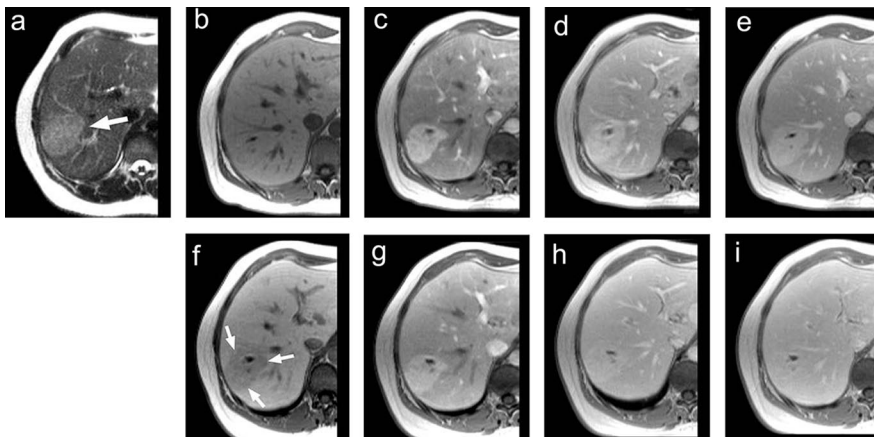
Hepatic adenoma in a 37-year-old female patient. A large lesion (arrow) is clearly seen in liver segment VII as slightly hyperintense against the surrounding liver parenchyma on the unenhanced T2-weighted image (a) and as isointense on the unenhanced T1-weighted image (b). During the arterial phase at 25 seconds after the first injection of 0.05 mmol/kg gadobenate dimeglumine (c), the lesion appears as strongly hyperintense. Thereafter, during the portal-venous phase at 60 seconds (d) and the equilibrium phase at 5 minutes (e) after injection the lesion demonstrates persistent hyperintensity due to contrast agent pooling in a manner similar to that observed with FNH. Unlike the enhancement behavior observed with FNH, the adenoma (arrows) is seen as hypointense against the enhanced normal parenchyma on the delayed phase image (f) acquired at 60 minutes postinjection. A similar pattern of enhancement to that seen during the first dynamic series is also seen during a second dynamic series (g, h, and i) acquired after a second injection of 0.05 mmol/kg gadobenate dimeglumine. However, the enhanced normal parenchyma at this time results in reduced lesion conspicuity, particularly on the portal-venous (h) and equilibrium (i) phase images.
